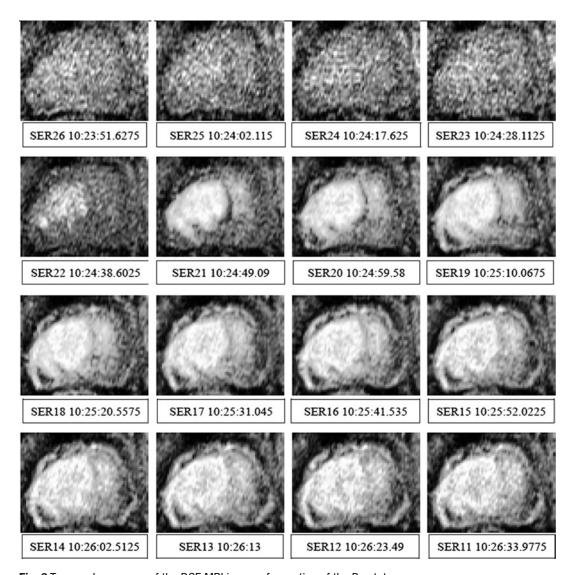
Temporal sequence of the DCE MRI image of a section of the Prostate
